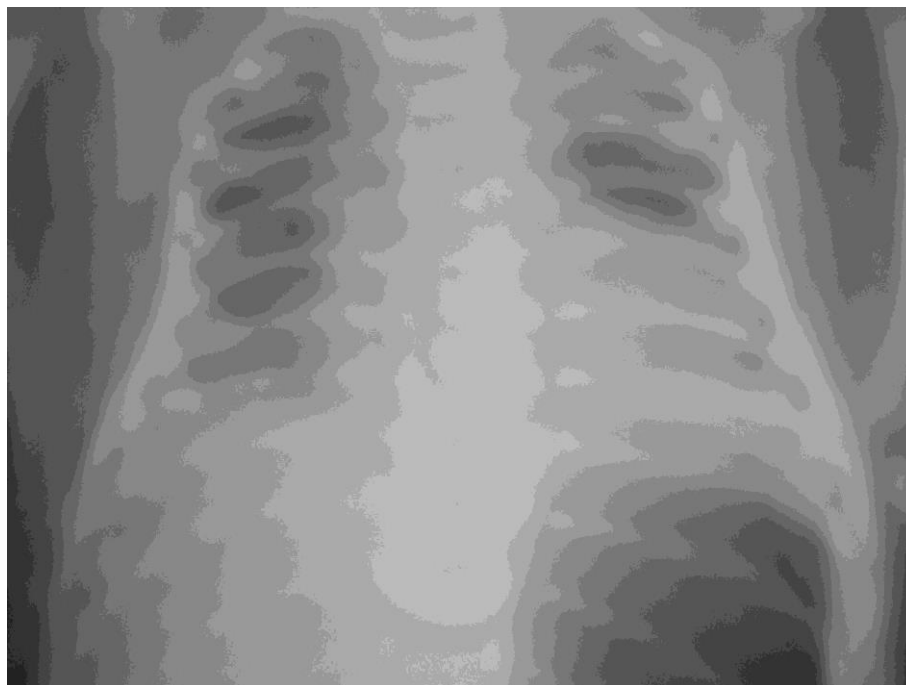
Radiograph of child Sh. upon admission, 3 days old. Gestation period 36-37 weeks. Polysegmental pneumonia. Hypoventilation of the lungs. Heterogeneous limited darkening in the middle zones. "Air bronchogram" symptom on the left. Reticulate deformation of the pulmonary pattern. Limited areas of hyperairiness on both sides.
